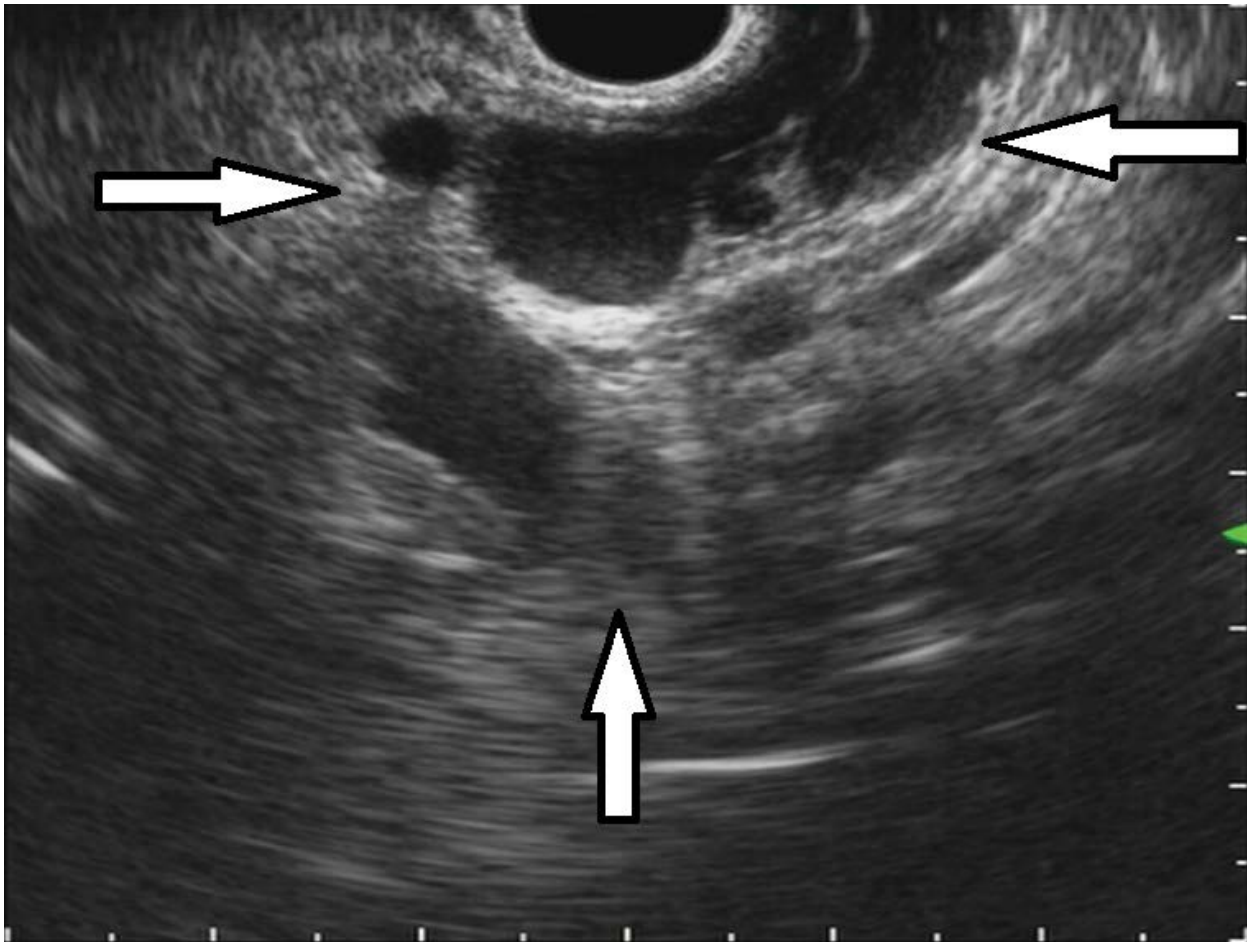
Endosonography showing a hypoechoic multicystic lesion with septa and central nodule in pancreatic tail.
